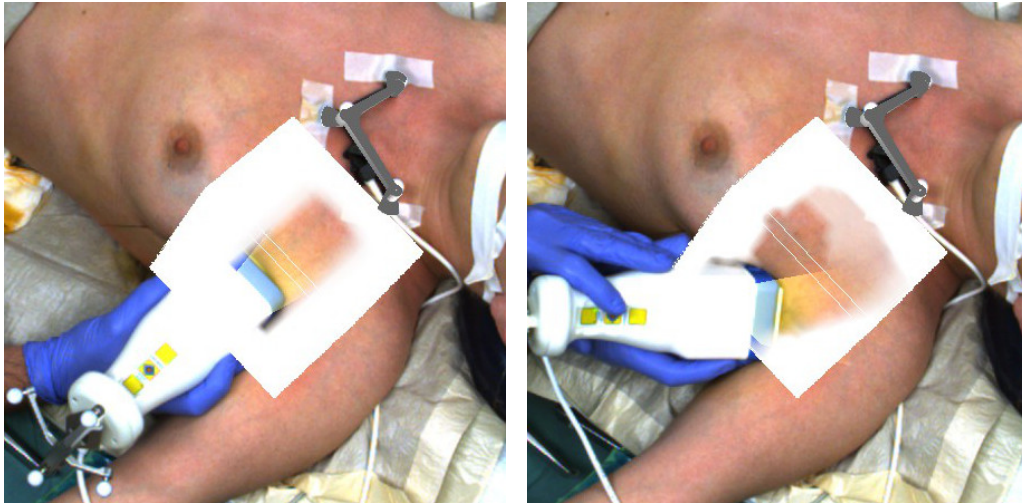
AR visualization during a Freehand SPECT acquisition (declipseSPECT Imaging Probe with gamma camera). The size of the volume of interest is predefined depending on the indication. User places the gamma camera at the center of the area to be scanned and starts the acquisition. The augmentation gets transparent as the user scans the area.
